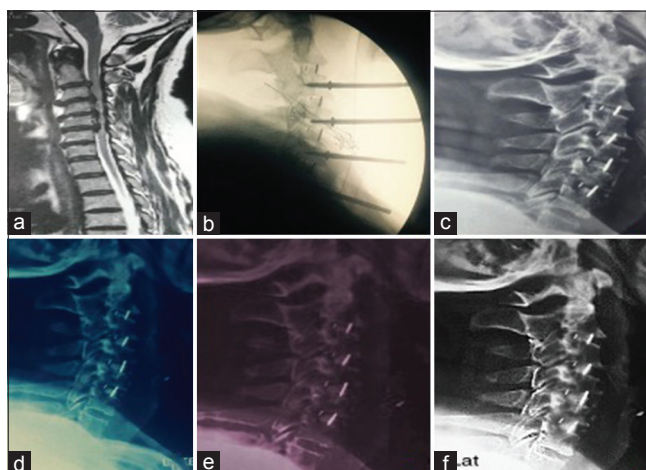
Type 1A fusion case “1A is defined as bridging bone anterior and through the disc space,” (a) magnetic resonance imaging of C2–C6 case, (b) intraoperative, (c) immediate postoperative, (d) 3-month follow-up, (e) 12-month follow-up, (f) 20-month follow-up
